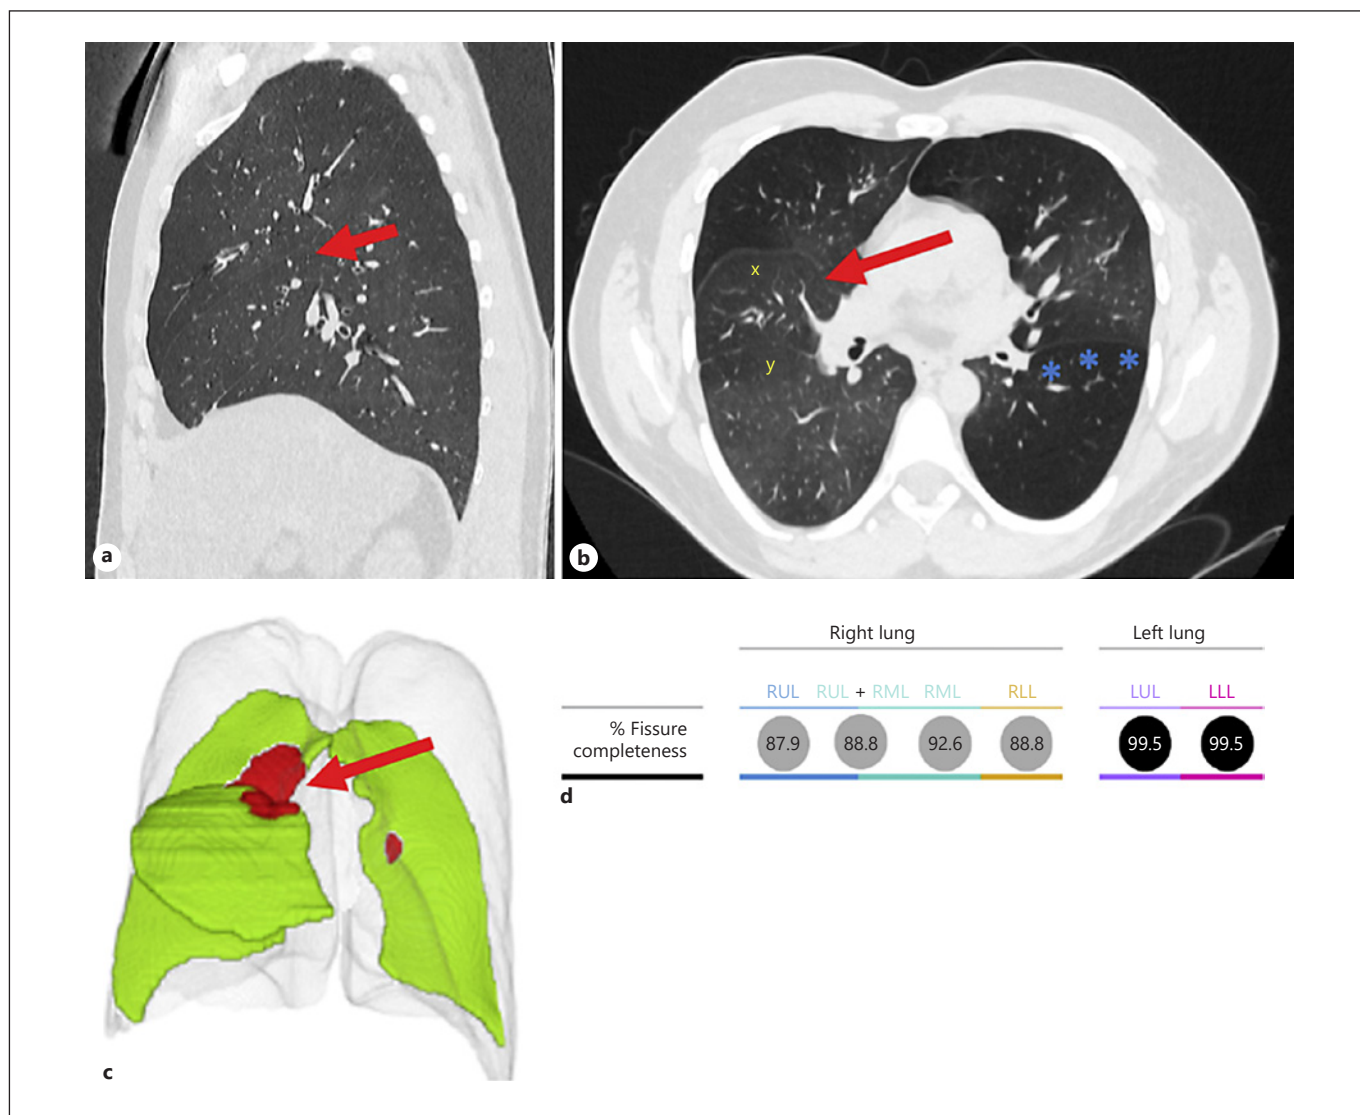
Patient example. Computed tomography (CT) of the thorax in sagittal (a) and transversal (b) reconstruction. a CT thorax. Sagittal reconstruction. The red arrow shows a small fissure defect. b CT thorax. Transverse reconstruction. “x” marks the right upper lobe fissure. “y” shows the right major fissure. The red arrow shows a small fissure defect. * indicates the (intact) left major fissure. c Software reconstruction of the lung fissures. The fissure defect is represented in red (red arrow). d Software-calculated fissure completeness score (FCS) for the right and left lung. The FCS of the right lung was intermediary between 80% and 95%. The FCS of the left lung was >95% representing a complete left major fissure.
